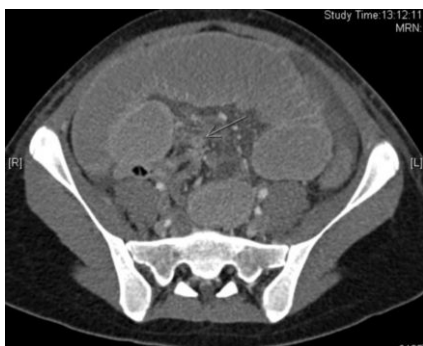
Computed tomography scan showing worsening small bowel dilatation and a transition point (green arrow) at the ileum.
